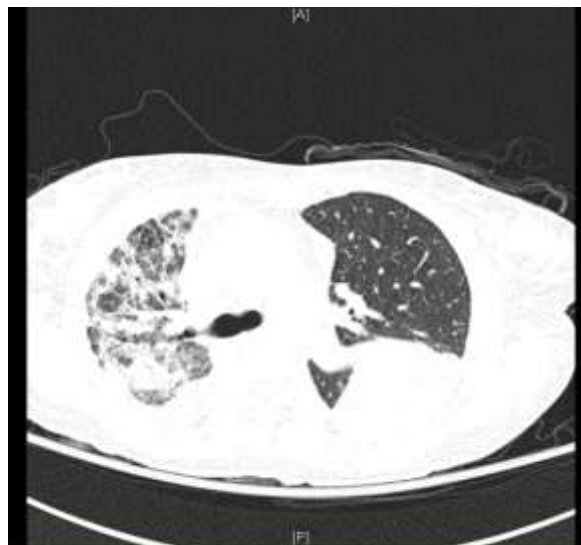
Chest Computed tomography scan (CT scan) showing diffuse right lung opacity, bilateral pleural effusion small amount in the right side and moderate and loculated in the left side and also cavity lesion in the left lower lung
